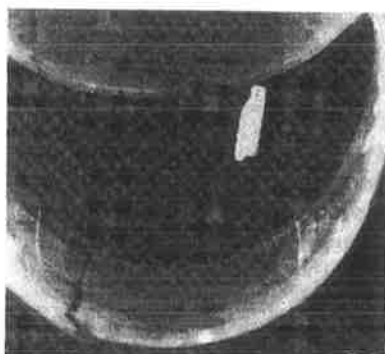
Plain radiograph showing face bar fracture on right (viewed from above).
